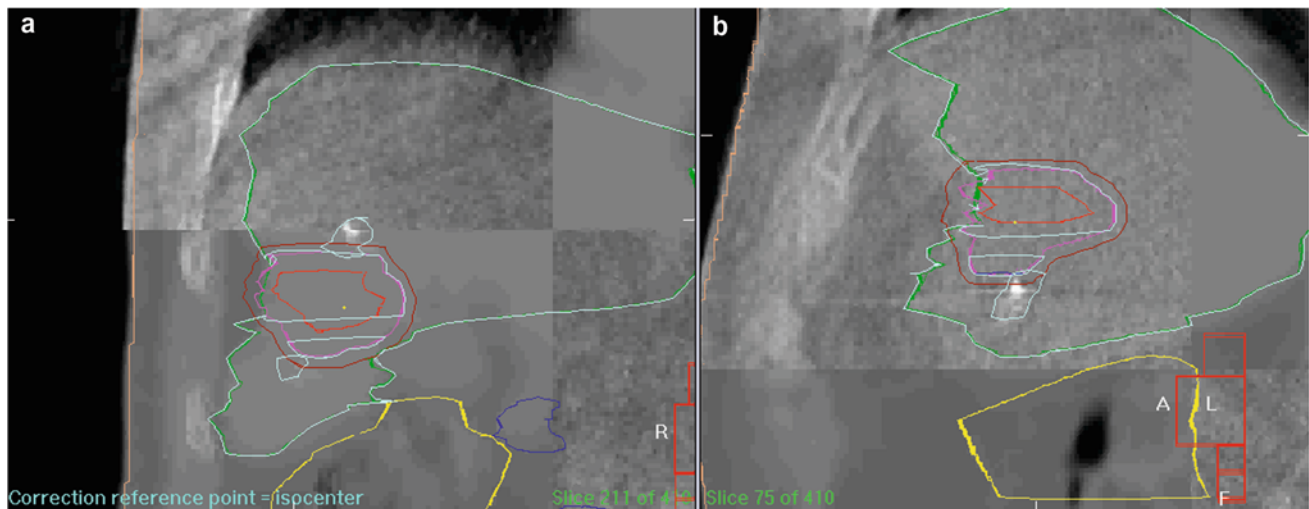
a Coronal and b sagittal cone-beam CT overlays from online imaging prior to a liver SBRT treatment. Quadrants a and c in each film represent the planning CT scan, while quadrants b and d represent the cone-beam CT taken at the time of delivery. The liver contour (*light*
